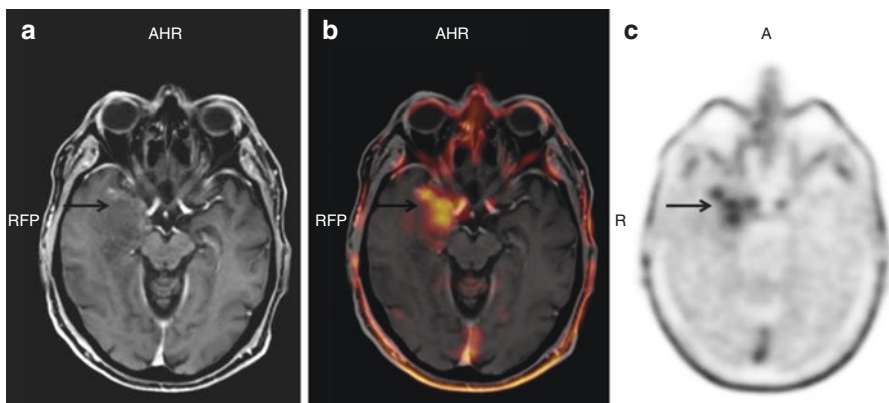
Axial MRI (a), fused ¹⁸F-FET PET/MRI (b) and ¹⁸F-FET PET (c) images in a 54 years old female patient with a suspicious right temporal glioma (arrows). ¹⁸F-FET PET shows an area of increased radiopharmaceutical uptake corresponding to the anterior portion of the cerebral lesion and suggesting a high-grade glioma, as confirmed by ¹⁸F-FET PET-guided biopsy. *Courtesy of Dr. Giorgio Treglia of the Oncology Institute of Southern Switzerland, Bellinzona, Switzerland*
